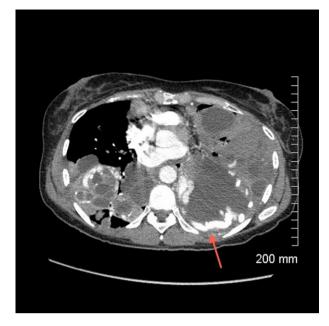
Computed tomography image showing expansion of pulmonary arteriovenous malformation after the drainage of the cyst. The pulmonary arteriovenous malformation now measures 11 to 12 mm in maximal diameter.
